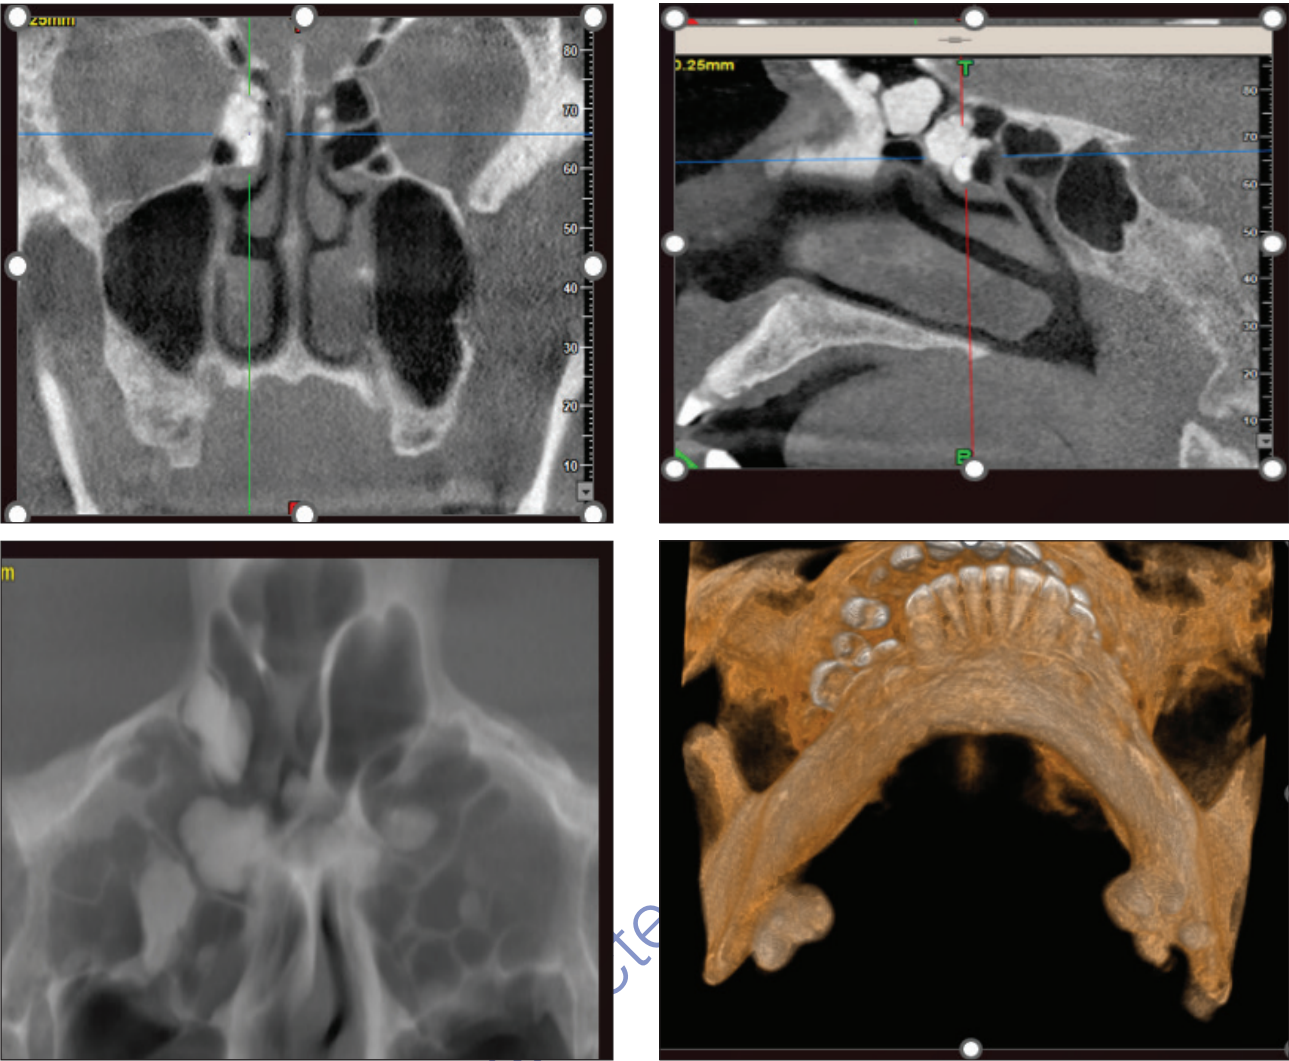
(a) Coronal CBCT. (b) Sagittal CBCT. (c) Multiplanar of CBCT. (d) 3D CBCT.
